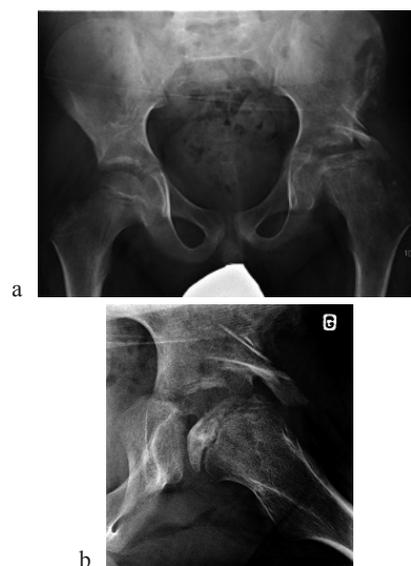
Two post-operative months (2M). (a) : Anteroposterior pelvic radiograph. The patient was classified Herring B at the fragmentation stage. As it is shown, a shelf gap is present at this stage. An augmentation of TAd and a reduction of MI is also seen. (b) : Lateral view of the left hip. The shelf gap is better appreciated.
